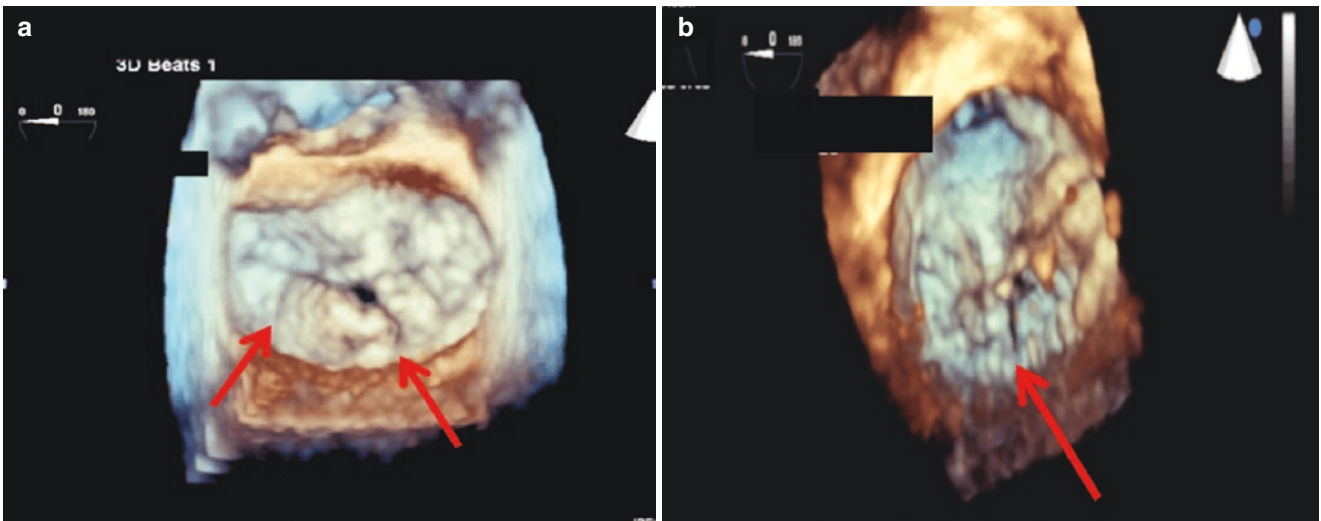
3D echocardiography can be utilized to identify mitral clefts, which would not be seen on 2D TEE. Panel a demonstrates 3D of the mitral valve showing indentations between the mitral scallops (red
